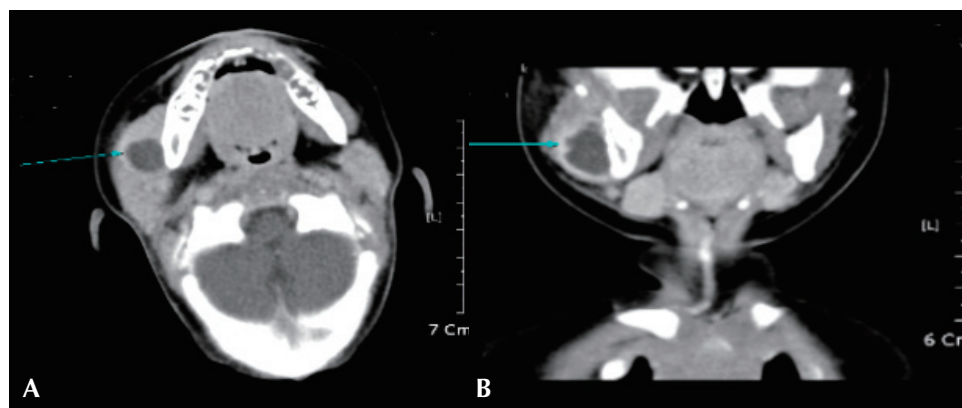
Computed tomography scan showed abscess formation (arrow) in the right masticator space combined with adjacent cellulitis at the 7th hospital day.
